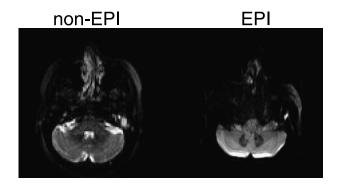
Comparison of the EPI and non-EPI DWI for the same cholesteatoma patient. The high-intensity region indicates a cholesteatoma, which are more clearly visualized in non-EPI DWI than in EPI DWI.
